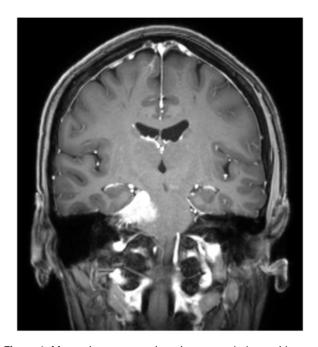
Magnetic resonance imaging coronal plane with contrast. See the contrast-enhanced meningioma located at the right cerebellopontine angle. The size of the tumor is 21.9 \times 30.1 \times 23 mm (craniocaudal, anteroposterior, and transversal, respectively). See the mass effect compressing the ipsilateral protuberance site and the V cranial nerve root.
